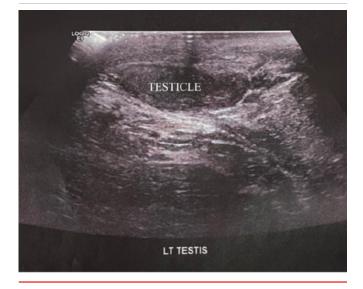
Scrotal Ultrasound of Testicular Mass (left testicular view). Published with Permission.
